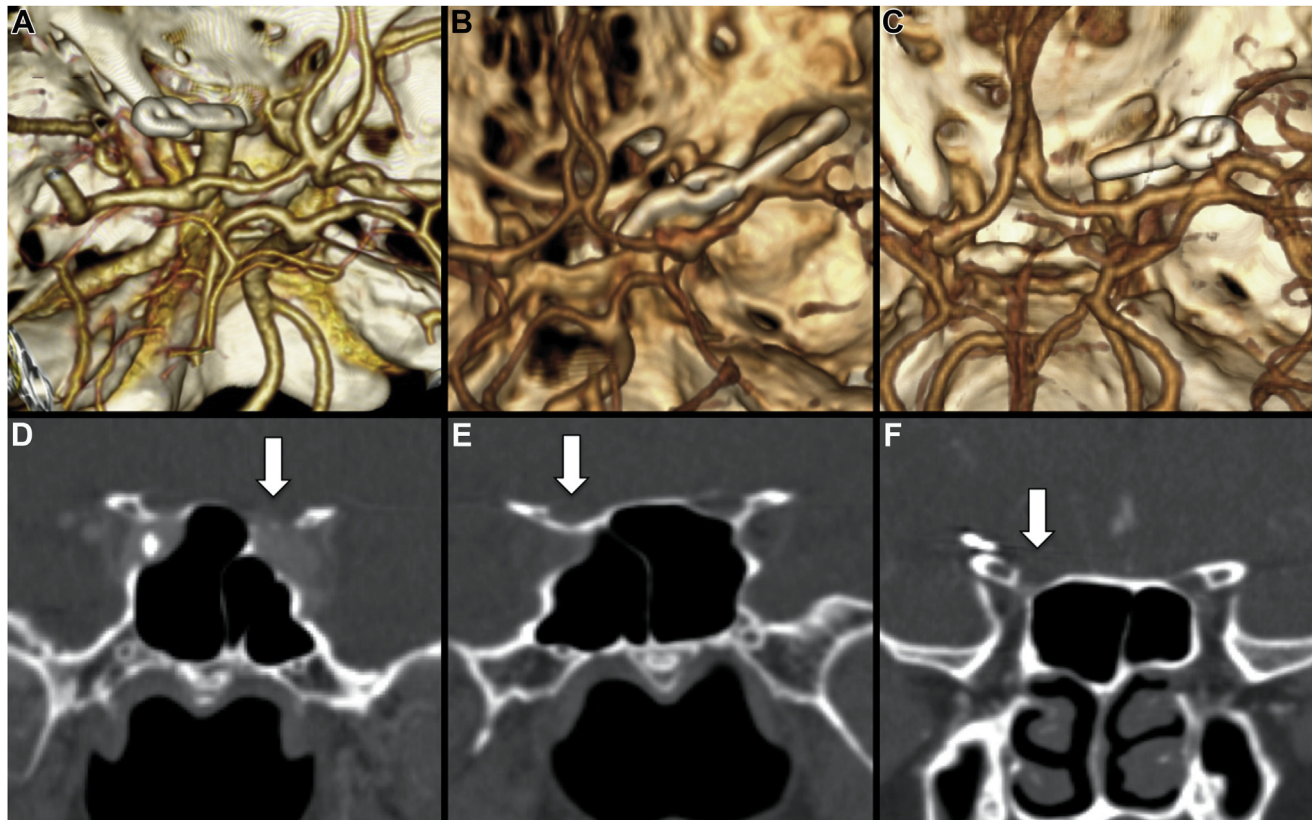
Postoperative computed tomography reconstructions of patient 1: (A) postoperative computed tomography (CT) angiographic reconstruction showing a straight clip occluding the left superior carotid–ophthalmic aneurysm and (D) postoperative coronal 1-mm-cut CT reconstruction showing optic foraminotomy on the left side (*white arrow*). Postoperative CT reconstructions of patient 2: (B) postoperative CT angiographic reconstruction showing a straight clip occluding the right superior carotid–ophthalmic aneurysm and (E) postoperative coronal 1-mm-cut CT reconstruction showing optic foraminotomy on the right side (*white arrow*). Postoperative CT reconstructions of patient 3: (C) postoperative CT angiographic reconstruction showing a straight clip occluding the right superior carotid–ophthalmic aneurysm and (F) postoperative coronal 1-mm-cut CT reconstruction showing optic foraminotomy on the right side (*white arrow*).
